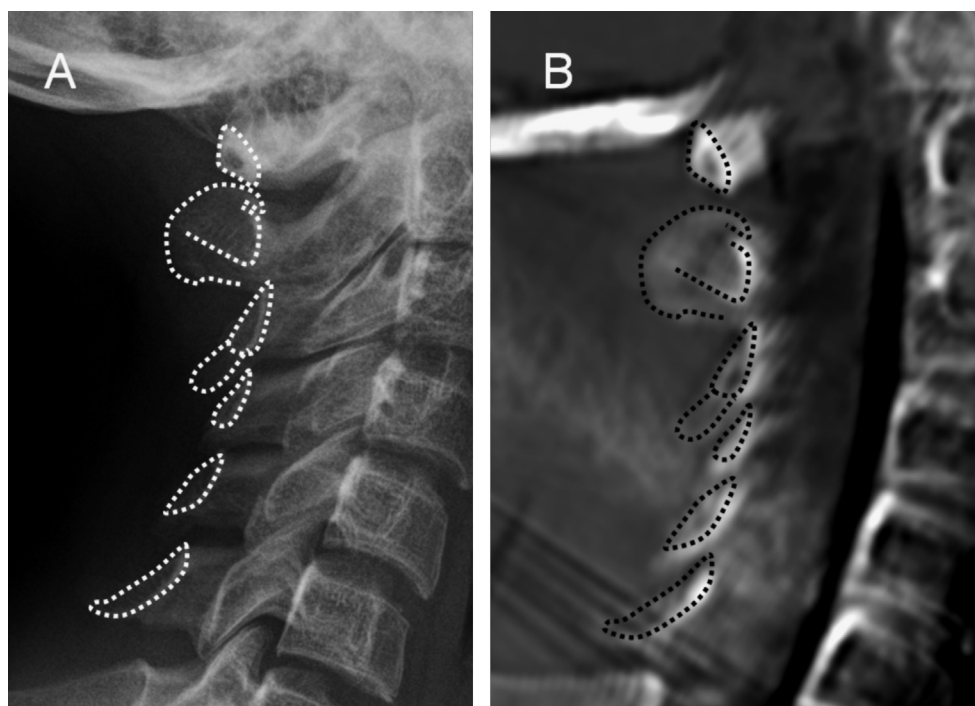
RADid using normal anatomy – cervical spine posterior elements. (A) AM lateral cervical spine radiograph. (B) PMCT – pseudo-radiograph created with thick slab MPR using mean rendering and matched to the orientation of the AM image. The matching cortical outlines of the posterior element anatomy were used in this ID, indicated by the dotted lines. Severe thermal damage was present in the decedent, exhibited by low density areas of marrow rarification and cortical damage of the vertebral bodies (lower right in B) but this did not preclude ID in this case.
